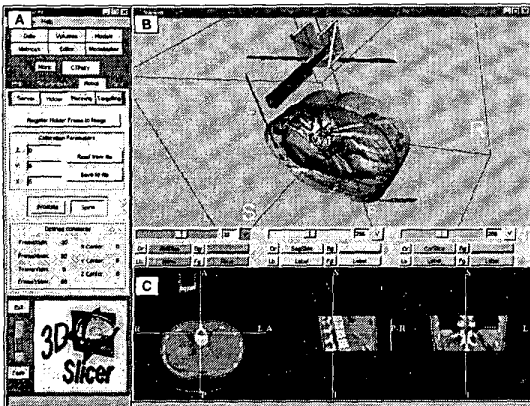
Visualization and treatment planning display for CT-guided robotically assisted spinal nerve blocks, using the end-effector shown in Figure 4D (Tanaacs et al., 2001)
